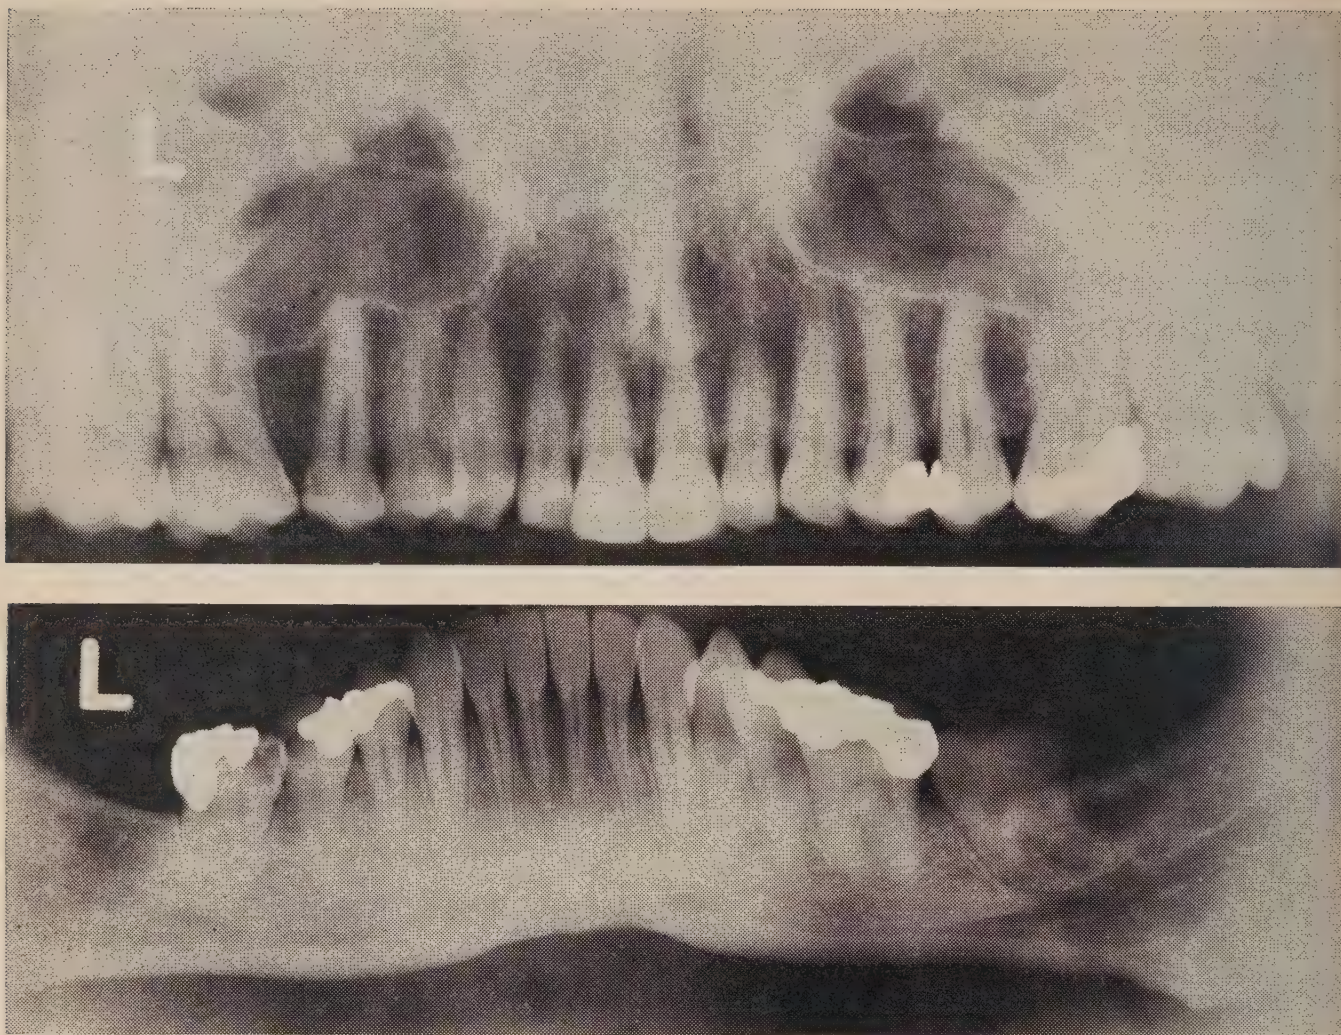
Maxillary and mandibular panoral radiographs produced by the Panoramix. (Updegrave, W.J. D. Radiog. & Photog. 36:75, 1963.)
